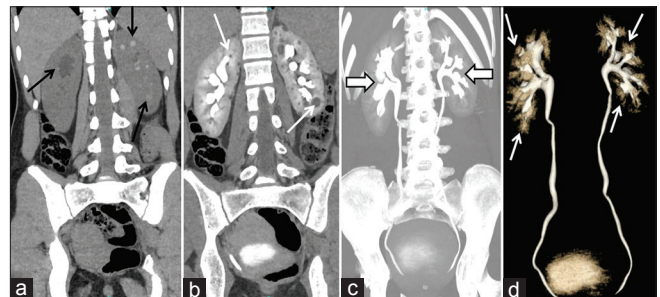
(a) Coronal noncontrast computed tomography (CT) image showing medullary calcifications in bilateral kidneys (black arrows) (b) coronal contrast-enhanced CT scan showing cysts in bilateral kidneys (white arrows) (c) thick-maximum intensity projection coronal sections showing papillary-blush pattern (arrowheads) (d) volume-rendered CT image showing bouquet of flowers appearance in the region of papilla in bilateral kidneys (arrows)
